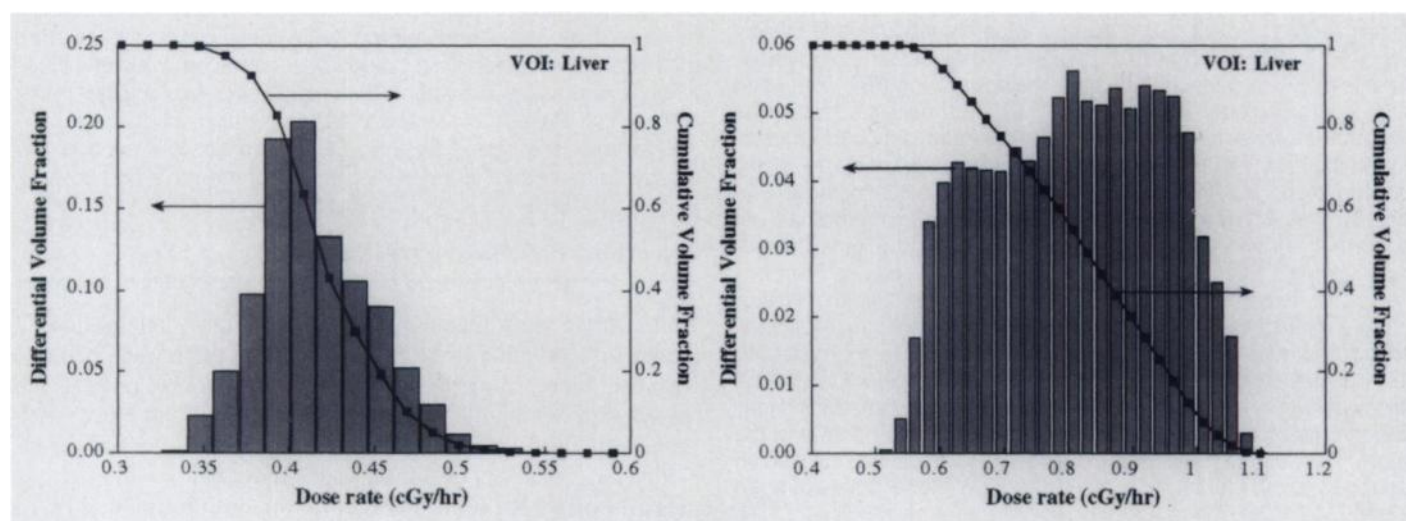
Examples of differential and cumulative dose-rate volume histograms for the liver based on quantitative SPECT imaging and 3D-DFT convolution for two patients who had undergone ^{131}I RIT. Mean absorbed dose rate and standard deviation were: (A) 0.42 and 0.06 (cGy/hr) and (B) 0.81 and 0.14 (cGy/hr), respectively.
